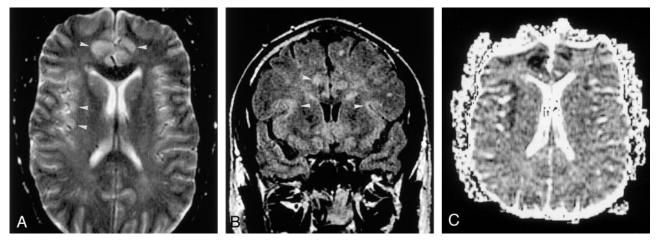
MR imaging in patient 3 obtained 10 days after the onset of symptoms.
